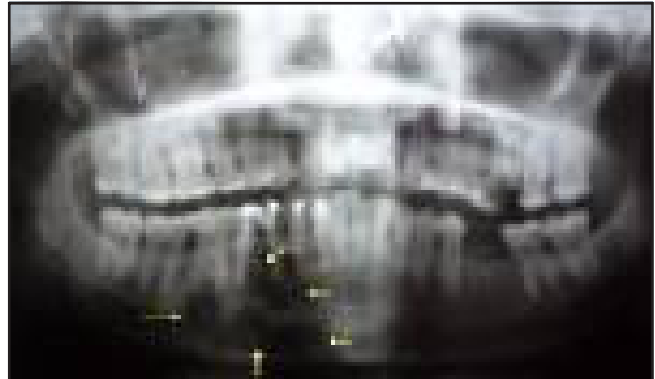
Panoramic radiograph showing lesion in the right mandible
